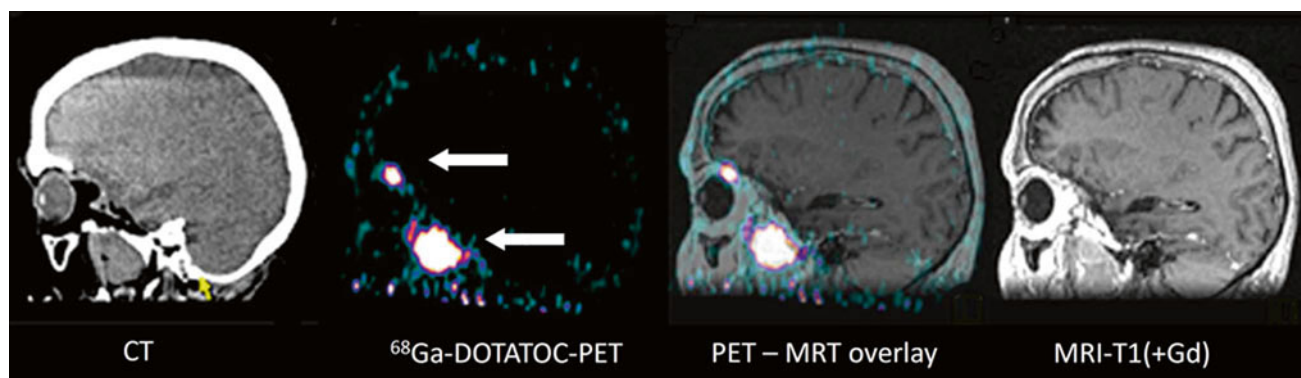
Patient with a recurrent skull base meningioma 2 years after resection. Both MRI and PET/CT indicate a tumor, but ^{68}Ga -DOTATOC PET shows an additional intraorbital lesion, which is not detectable by MRI (Courtesy of Michail Plotkin, Vivantes Clinics Berlin, Germany)
